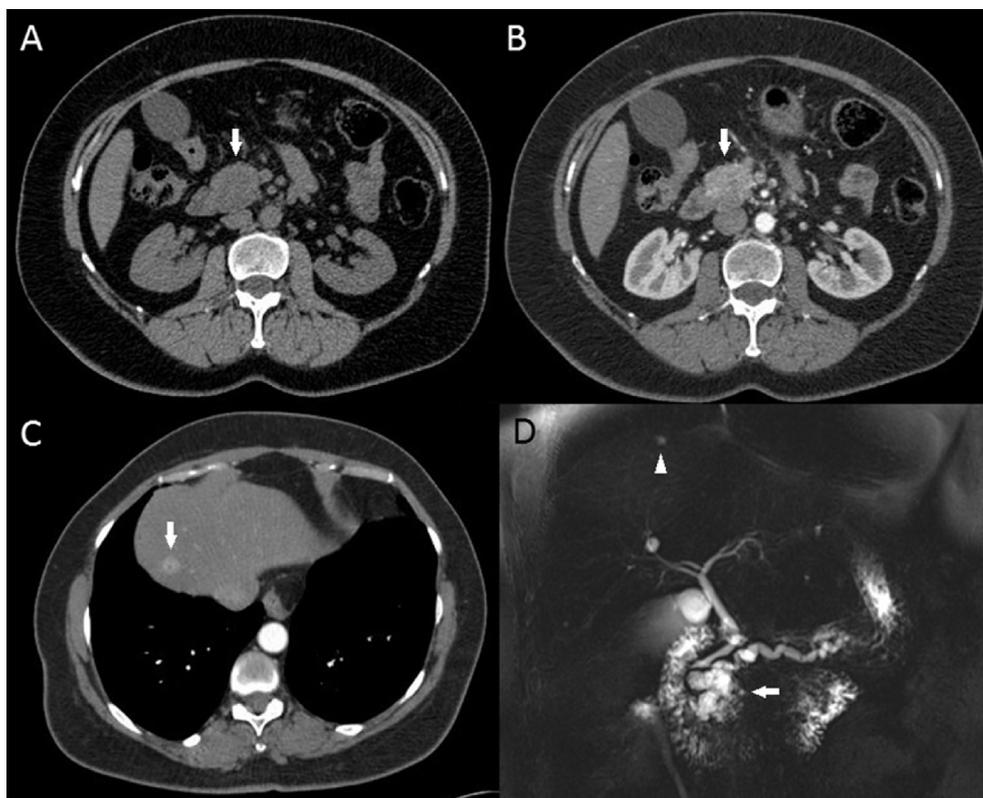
A) Non-contrast CT demonstrating a lobulated isodense mass in the pancreatic head (white arrow) adjacent to the superior mesenteric vein. B) Arterial phase of the CT pancreas protocol demonstrating the heterogeneous contrast enhancement of the solid component of the pancreatic mass (white arrow). C) Arterial enhancing lesion within the segment VIII of the hepatic dome, surgical proven metastases (white arrow). D) Cholangiography MR protocol T2 weighted demonstrating the cystic component of the pancreatic lesion (white arrow) causing dilation of the main pancreatic duct, up to 1.0 cm. Within the hepatic dome, the slightly high T2 weighted focus can also be appreciated (white arrow head), surgical proven metastases.
